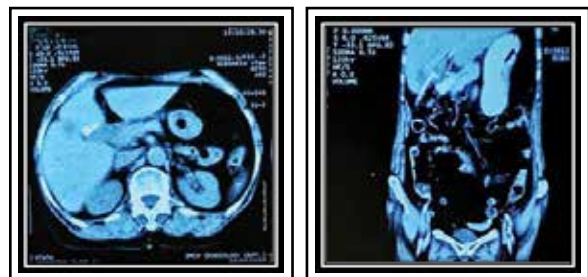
CT scan in January 2026
